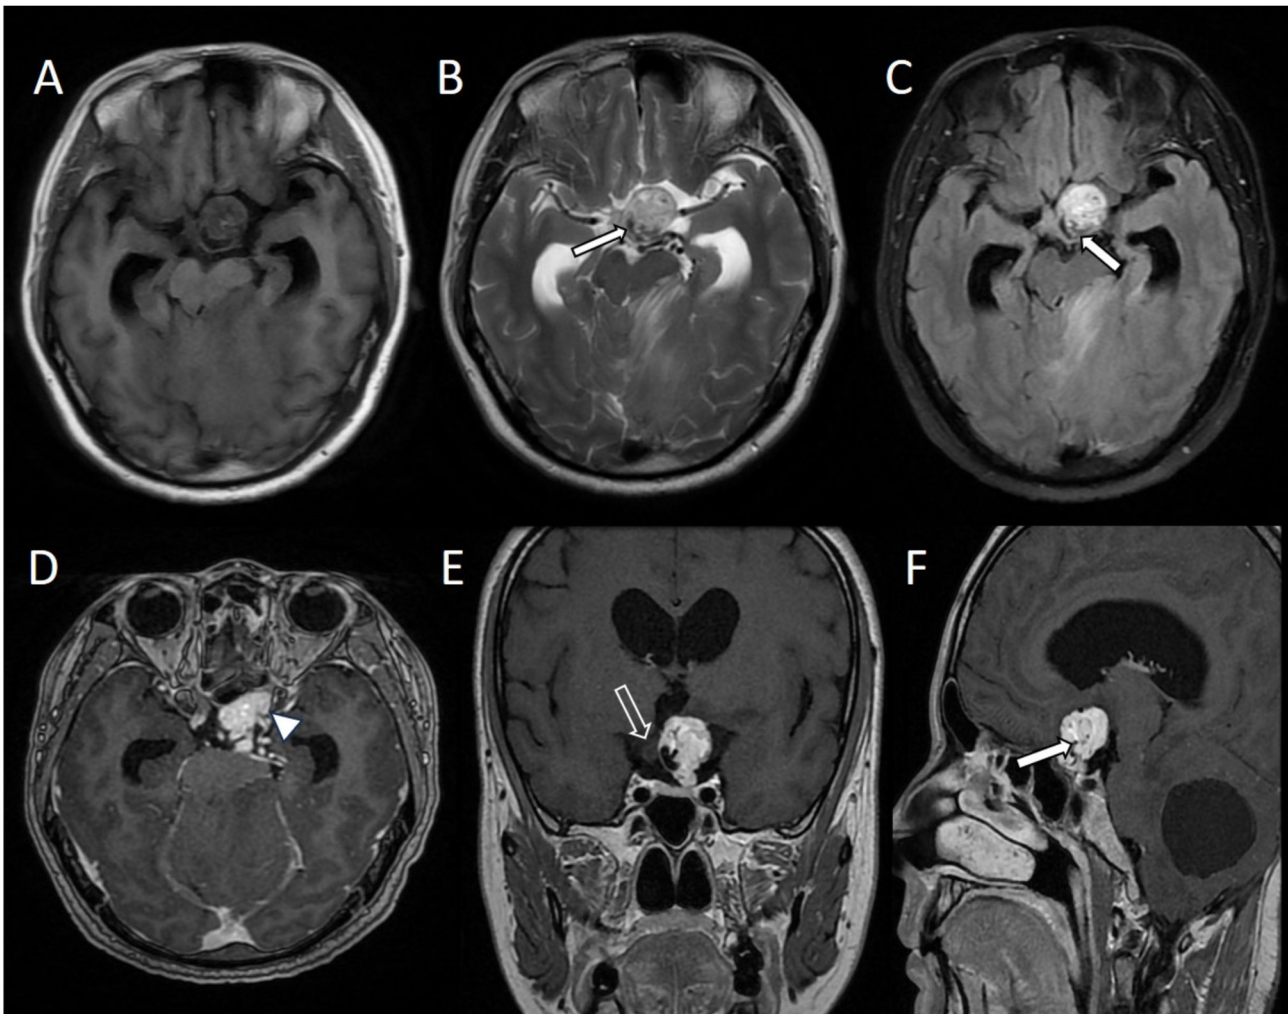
Preoperative MRI scans of the suprasellar lesion. (A) Axial T1-weighted image depicting a heterogeneously hypointense suprasellar mass. (B) Axial T2-weighted image showing hyperintense signals for this lesion. (C) T2-weighted fluid-attenuated inversion recovery image showing that the lesion exhibited intrinsic hyperintensity. Contrast-enhanced (D) axial, (E) coronal and (F) sagittal images demonstrating that the lesion exhibited homogeneous signal enhancement, encasement of the left internal carotid artery and displacement of the optic chiasm. Filled arrows indicate flow voids, the arrowhead indicates encasement of the left internal carotid artery and the empty arrow indicates displacement of the optic chiasm.
